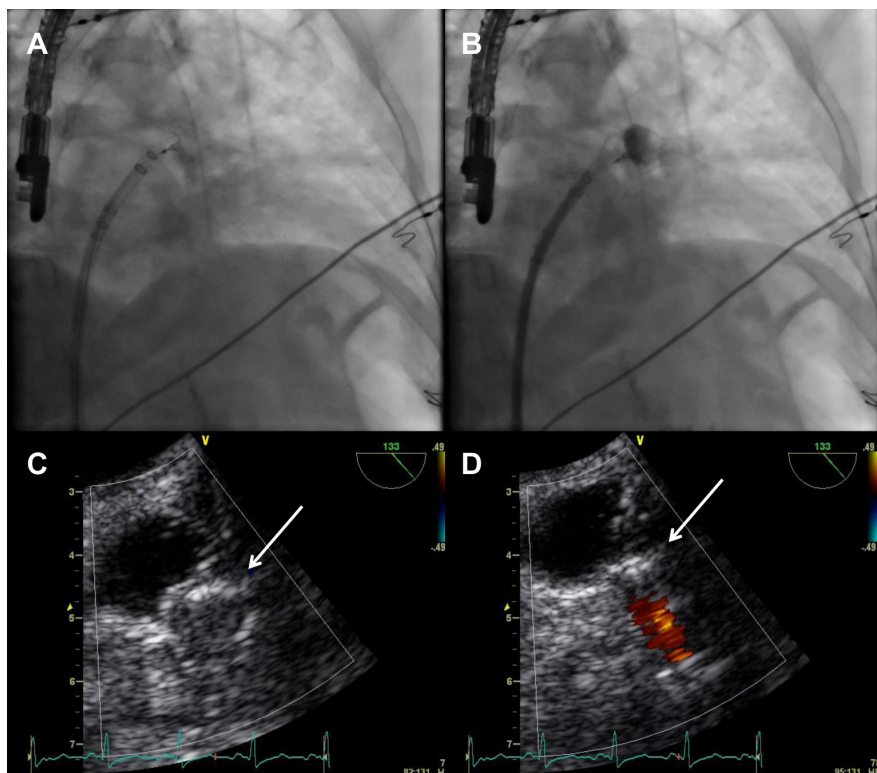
Placement of a WATCHMAN® left atrial appendage exclusion device. Panels A and B show transcatheter deployment (Panel A) and contrast injection (Panel B) in the left atrial appendage, without evidence of contrast leaking. The correct positioning of the device is confirmed by real-time transesophageal echocardiography (Panels C and D), which confirms absence of leaking by Color Doppler study (Panel D).
